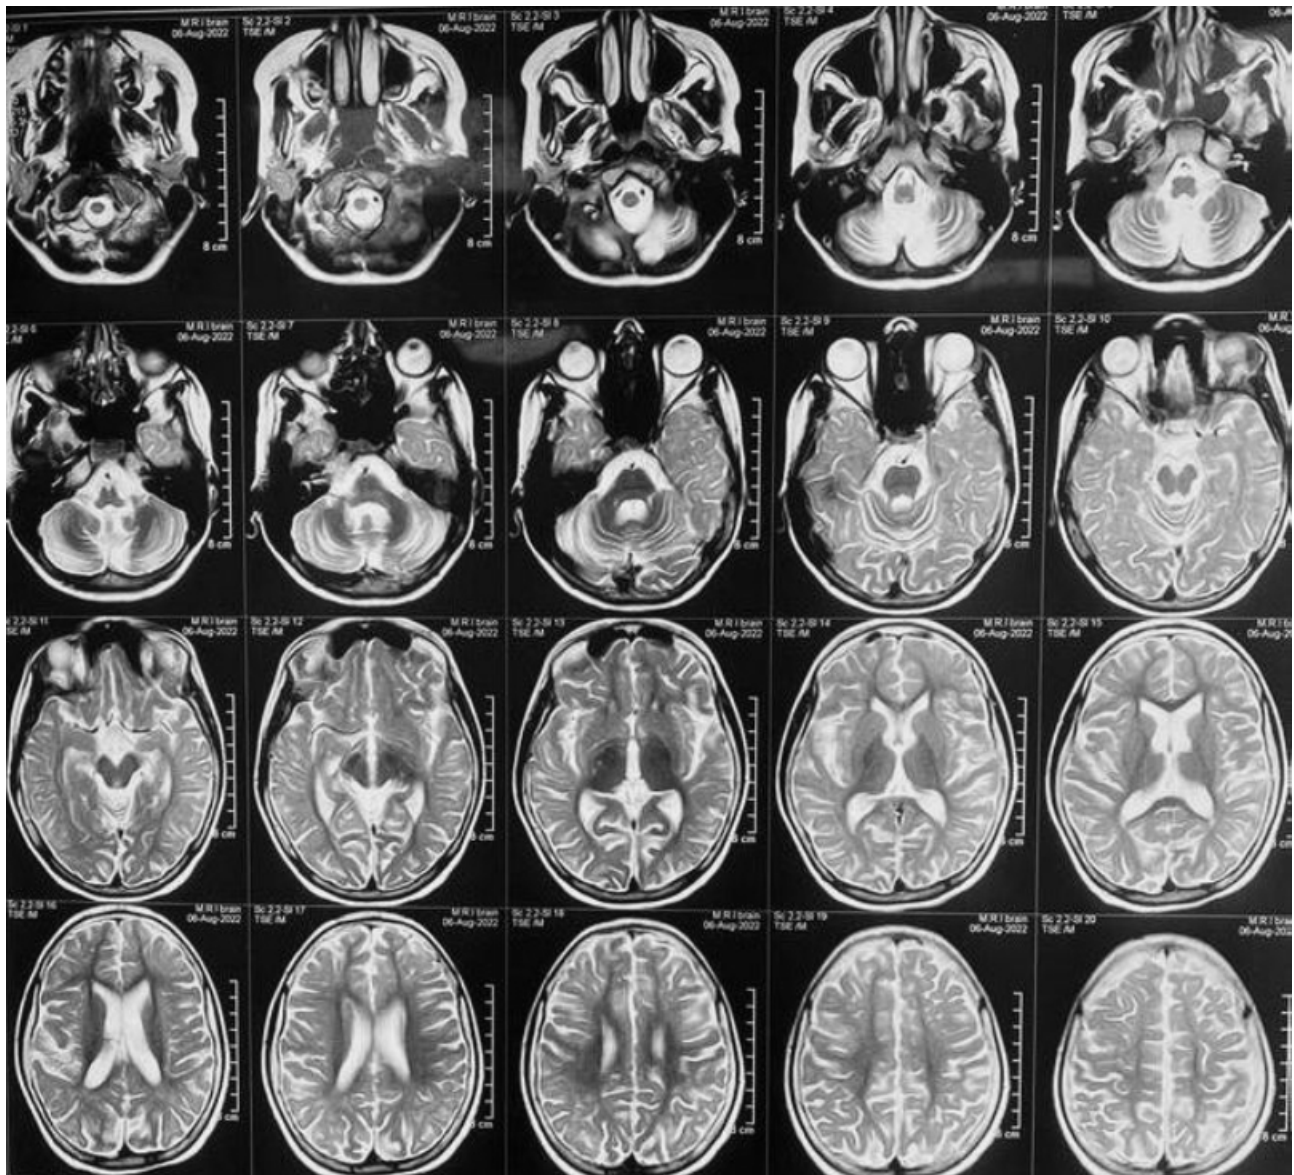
MRI brain (T2) revealed diffuse cerebral and cerebellar atrophy. MRI, magnetic resonance imaging.
